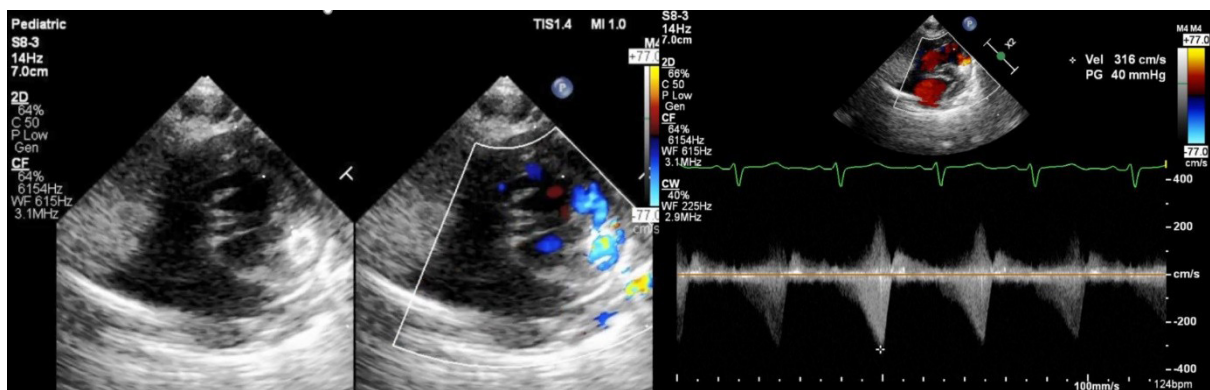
Post-procedural echocardiography showing the device well positioned in place with a reduced pulmonary stenosis gradient.
